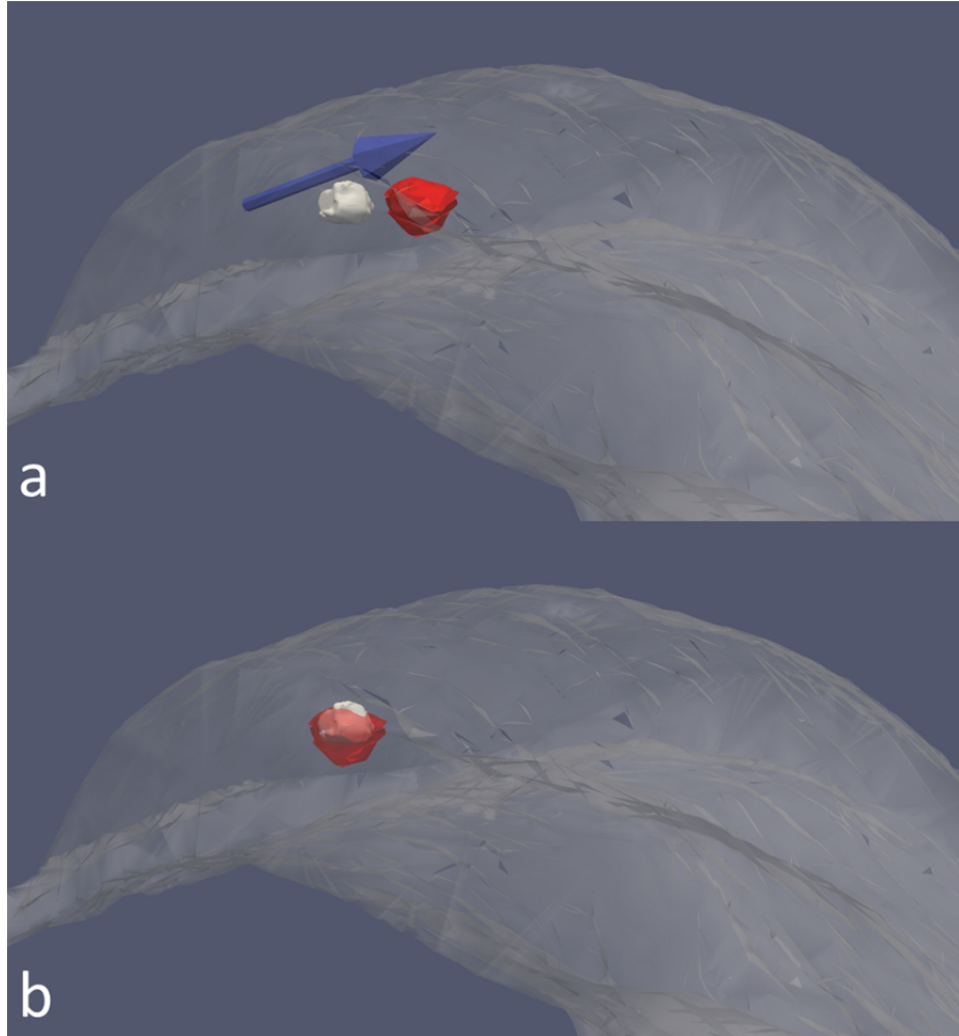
Example of an ultrasound cyst surface (red) misaligned with the corresponding MR surface, with the prior swab trajectory visualized as a blue arrow (a). The known vector of misalignment between the ultrasound and MR centroids was computed and the closest vector in the previous three seconds of tracking data was used to translate the ultrasound cyst to an earlier position in the swab.
